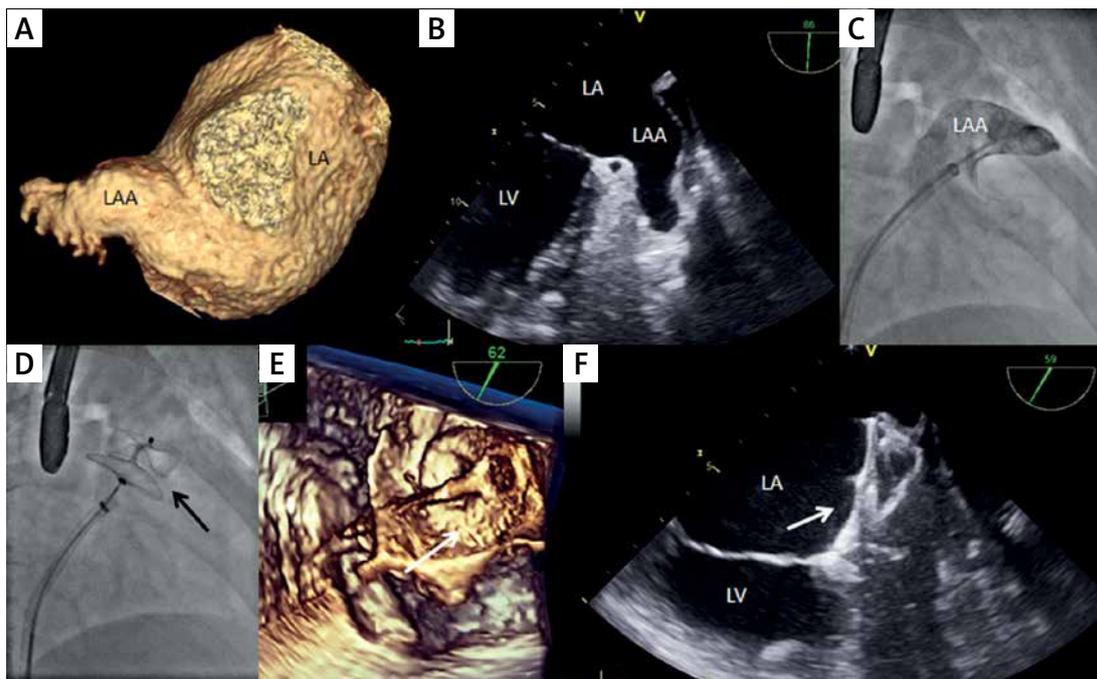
A – computed tomography angiography: 3D volume rendering of the left atrium (LA) and the left atrial appendage (LAA); B – transesophageal echocardiography: 2D imaging of the left atrium (LA), the LAA and the left ventricle (LV); C – fluoroscopy: LAA angiography; D – fluoroscopy: Amplatzer AMULET (arrow) deployed in the left atrial appendage, but still attached to a delivery system; E – transesophageal echocardiography: 3D imaging of Amplatzer AMULET (arrow) deployed in the left atrial appendage, but still attached to a delivery system – en face view; F – transesophageal echocardiography: 2D imaging of the Amplatzer AMULET (arrow) implanted in the left atrial appendage – 3-month follow-up
